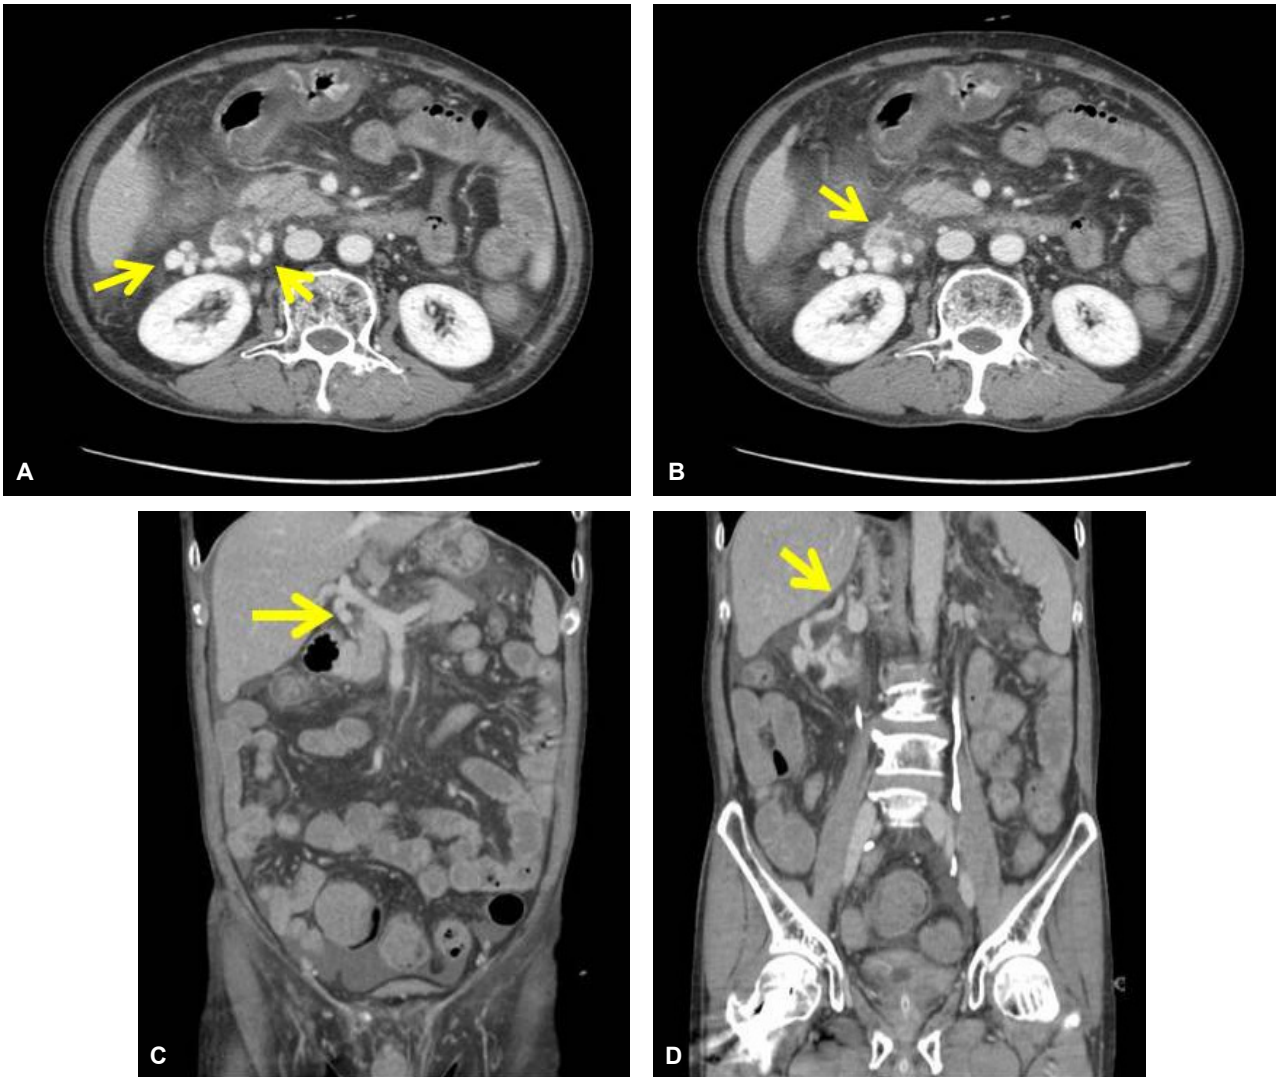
Initial abdominal CT results. (A) Venous collaterals (arrow) around the duodenum. (B) Extravasated contrast (arrow) in the second and third portions of the duodenum. (C) The afferent collateral vessel (arrow) originated directly from the main portal vein. (D) The efferent collateral vessel (arrow) drained throughout the inferior vena cava via the right renal vein.
